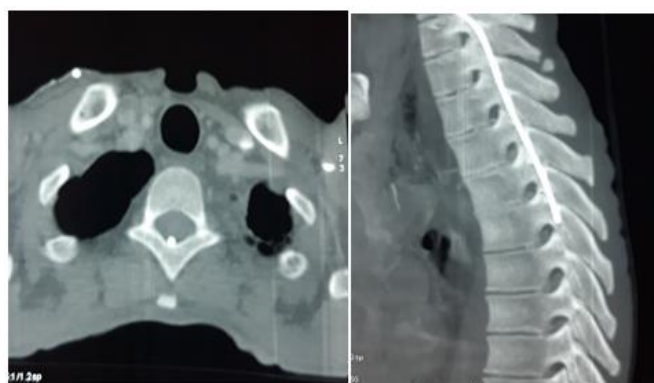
CT scan with image reconstruction an intra-dural position and extra medullary of the distal part of the catheter.
